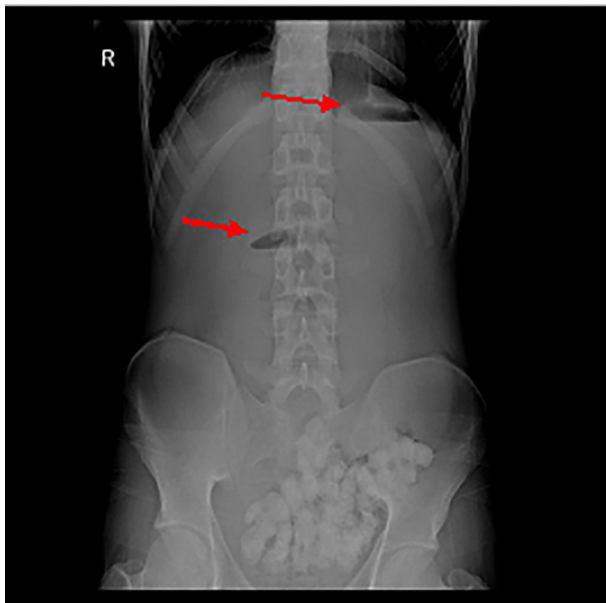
Frontal Radiograph of the abdomen, the double bubble sign (Red arrows).
